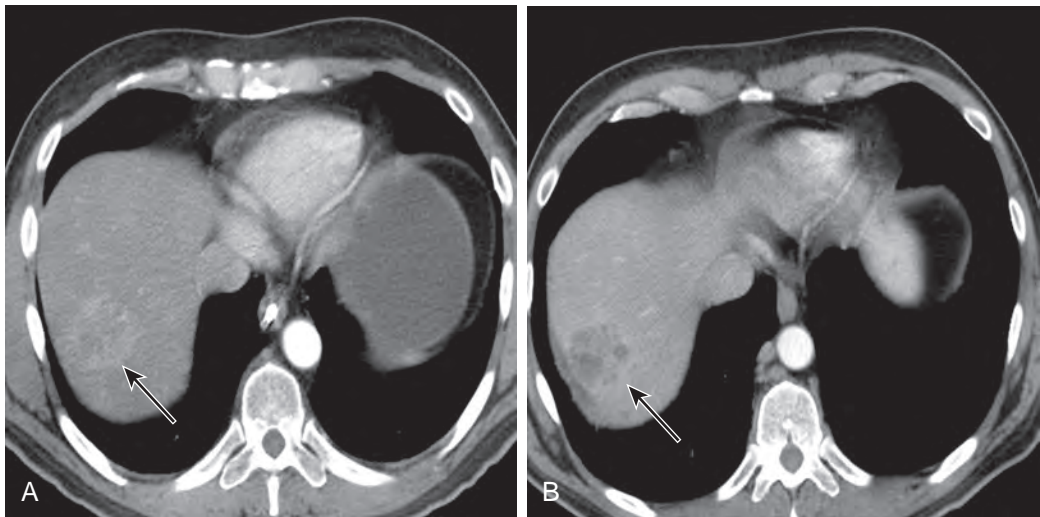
Choi criteria in gastrointestinal stromal tumor. Axial contrast-enhanced CT images in a patient with metastatic gastrointestinal stromal tumor before (A) and after (B) treatment with imatinib mesylate. Hepatic metastasis (arrows) measured 3.2 cm with attenuation of 145 HU on initial scan (A) and 3.0 cm with attenuation of 84 HU on follow-up scan (B). These findings were considered stable disease according to RECIST 1.1 and partial response according to Choi criteria.
